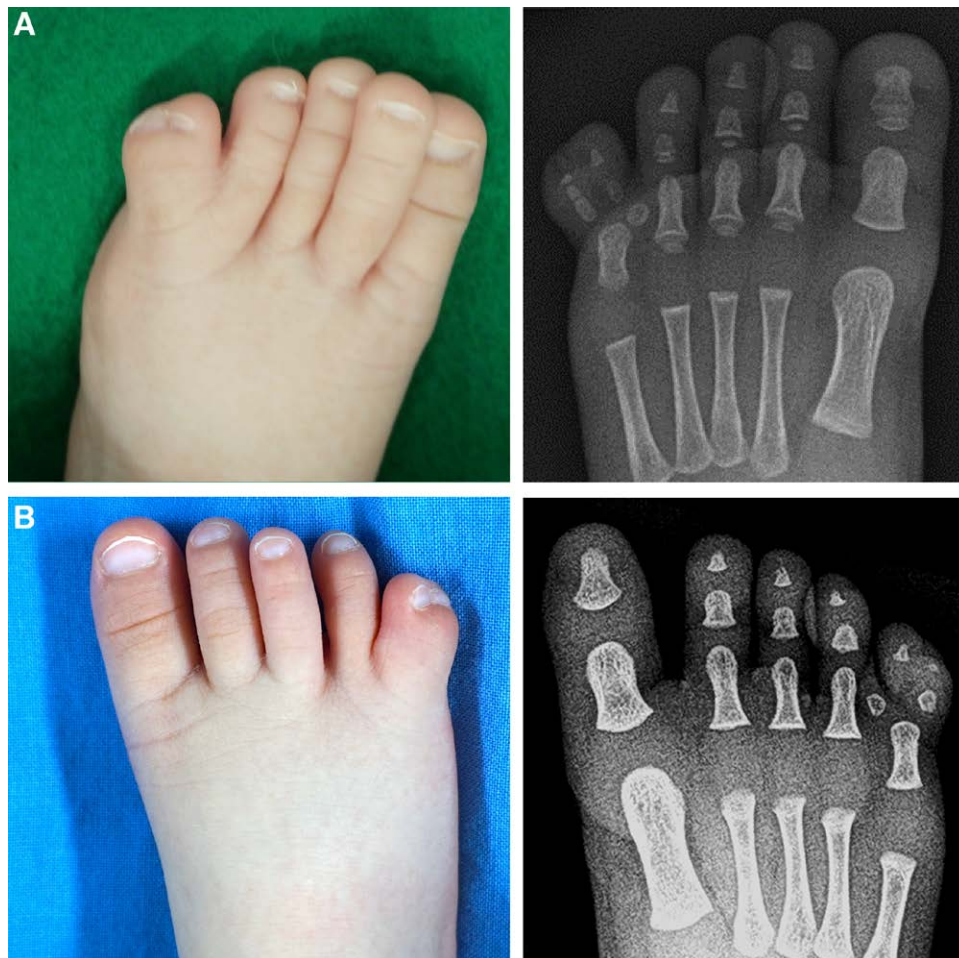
A, Preoperative photograph and radiograph of excess bone case (Case 3). B, Preoperative photograph and radiograph of mosaic-like alignment case.
